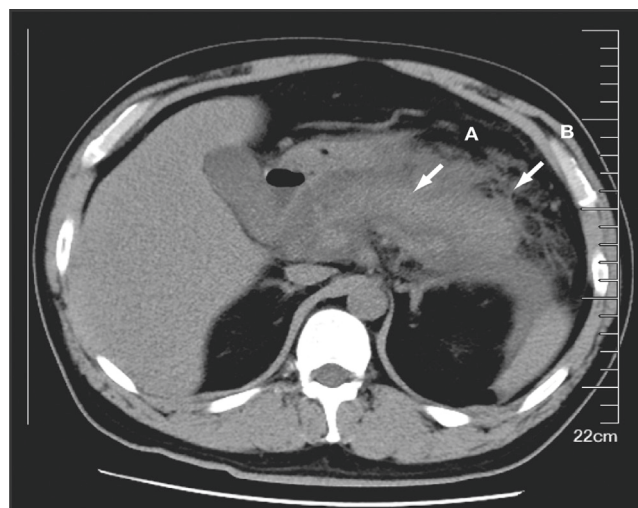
Axial computed tomographic image of the abdomen shows pancreatic enlargement (A) and peripancreatic exudative fluid (B).
